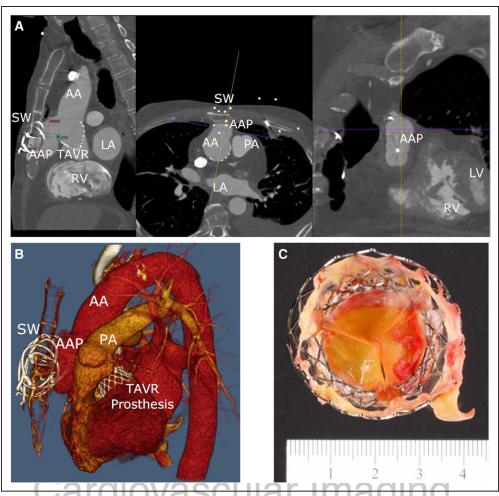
Computed tomography (CT) chest angiogram showing the aortic pseudoaneurysm and pathological exam of the explanted transcatheter aortic valve replacement (TAVR) prosthesis.
